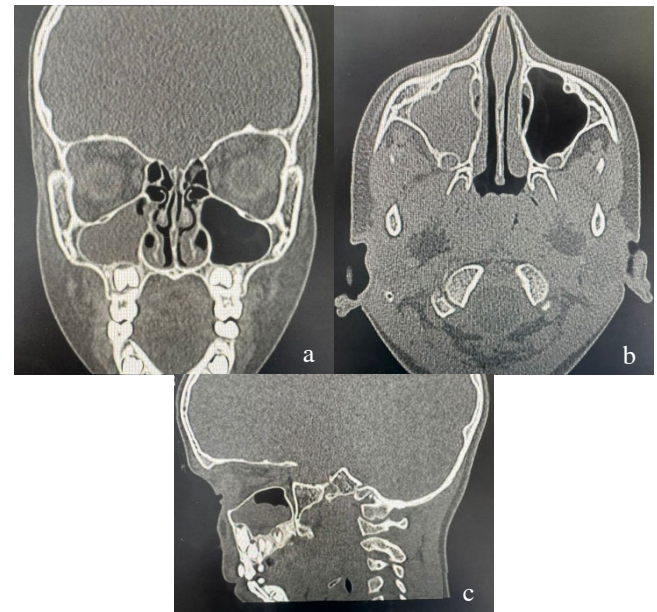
(a,b,c): (a) Coronal view. (b) Axial view. (c) Sagittal view of computed tomography scan shows mucosal thickening of the right maxillary sinus, with the mucosa extending superiorly and nearly filling the antrum.
